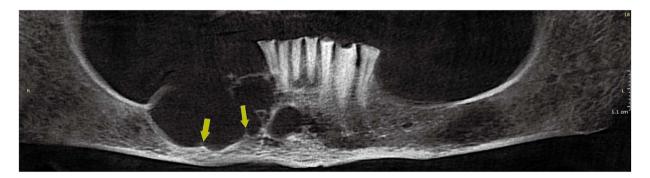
Central giant cell granuloma extends from the right first molar to the midline of the mandible. Panoramic reconstructed cone-beam computed tomographic image with 2-mm thickness shows scalloped borders (arrows).
